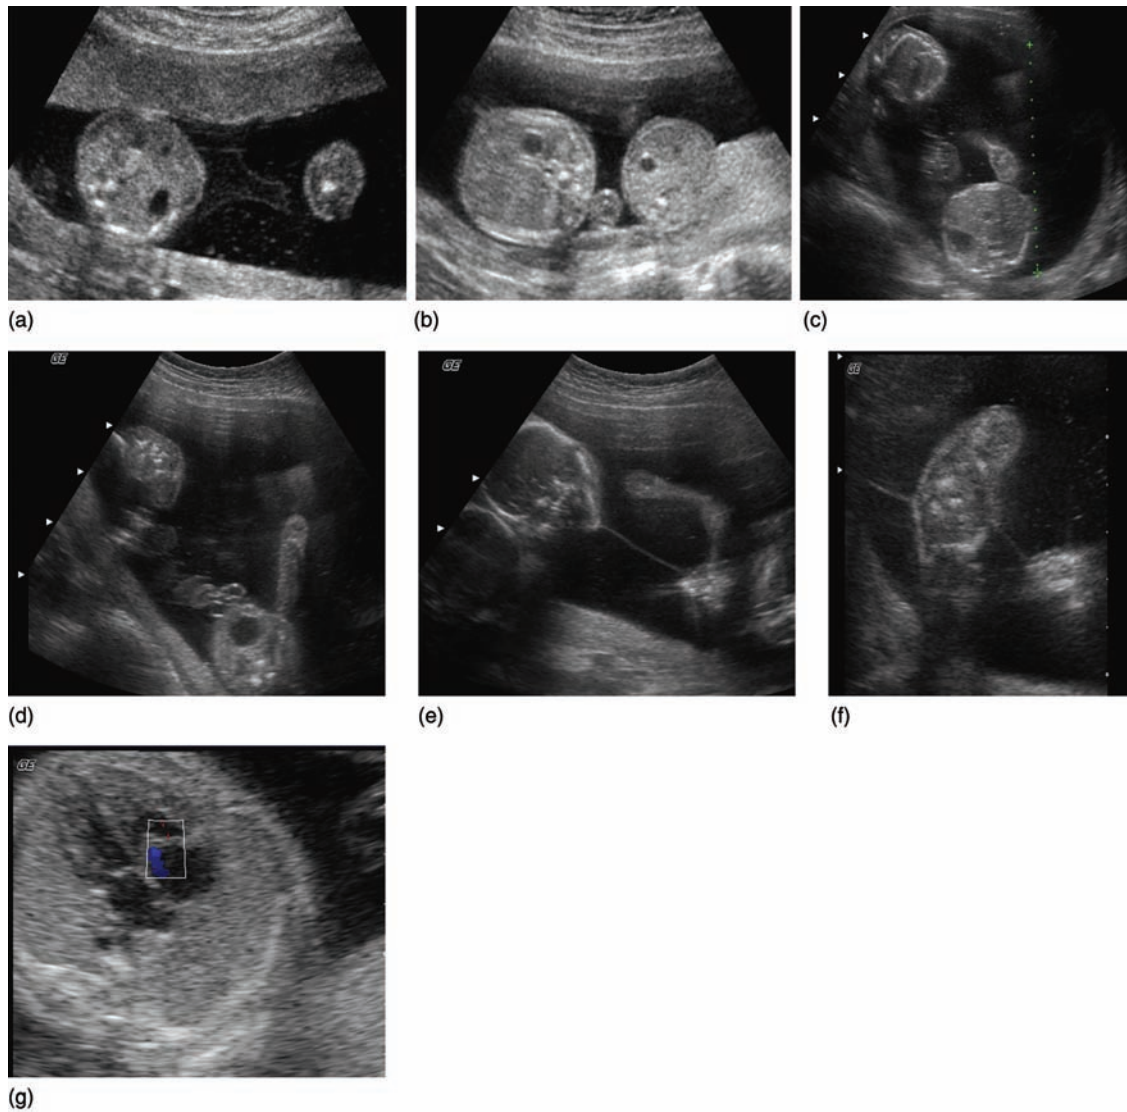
(a) Folding of the membranes (arrow) in a monochorionic twin pregnancy at 17 weeks. (b) Cross-section through the fetal abdomen of two monochorionic twins discordant for growth at 20 weeks. (c) Cross-section through the fetal abdomen of the stuck donor twin in anhydramnios against the uterine wall (d) and the recipient twin in polyhydramnios (r) in twin-to-twin transfusion syndrome. (d) Cross-section through the fetal pelvis of the stuck donor and the recipient showing absent and distended bladder, respectively. (e) The donor in anhydramnios is wrapped in its membranes as shown in a sagittal plane (f) and in a cross-section through the pelvis showing an empty bladder. This 'sling-sign' could lead to the false impression that the amniotic fluid volume is normal on both sides of a floating intertwin membrane. (g) Examination of the recipient's four-chamber view of the heart with color Doppler showing tricuspid regurgitation.
